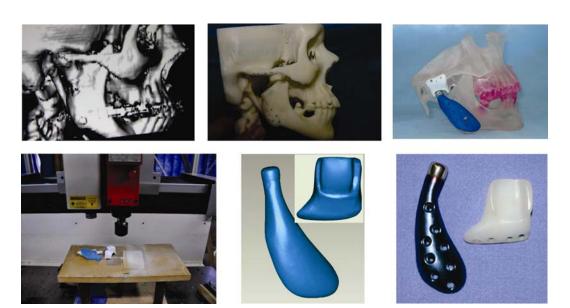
Manufacture of custom TMJ prosthesis. a) CT scan of the patient. b) Anatomical biomodel showing the removal of region to be replaced. c) Prosthesis prototype. d) Scanning of the components of the prototype. e) Virtual model. f) Final prosthesis, manufactured through CNC milling.
